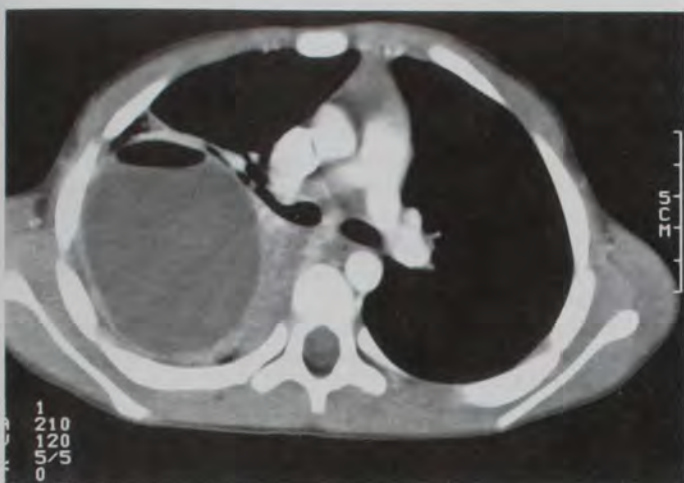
Preoperative computed tomography scan of the chest of case 1, demonstrating a 5 x 7 x 7 cm cystic lesion in the right upper lobe. An air fluid level is present within the lesion, and there is a suggestion of a communication with the right upper lobe bronchus.
